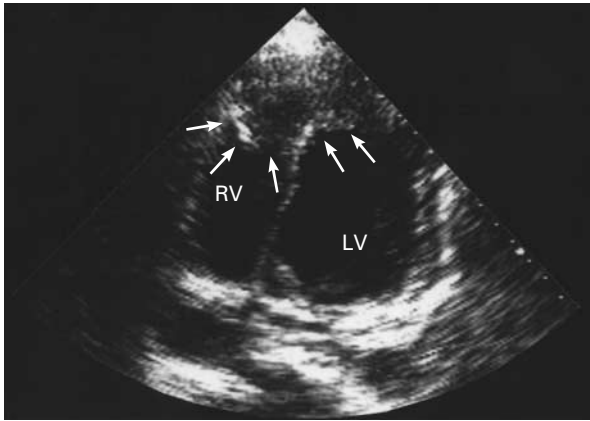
Two-Dimensional Echocardiogram Obtained after the Pericardiocentesis.
